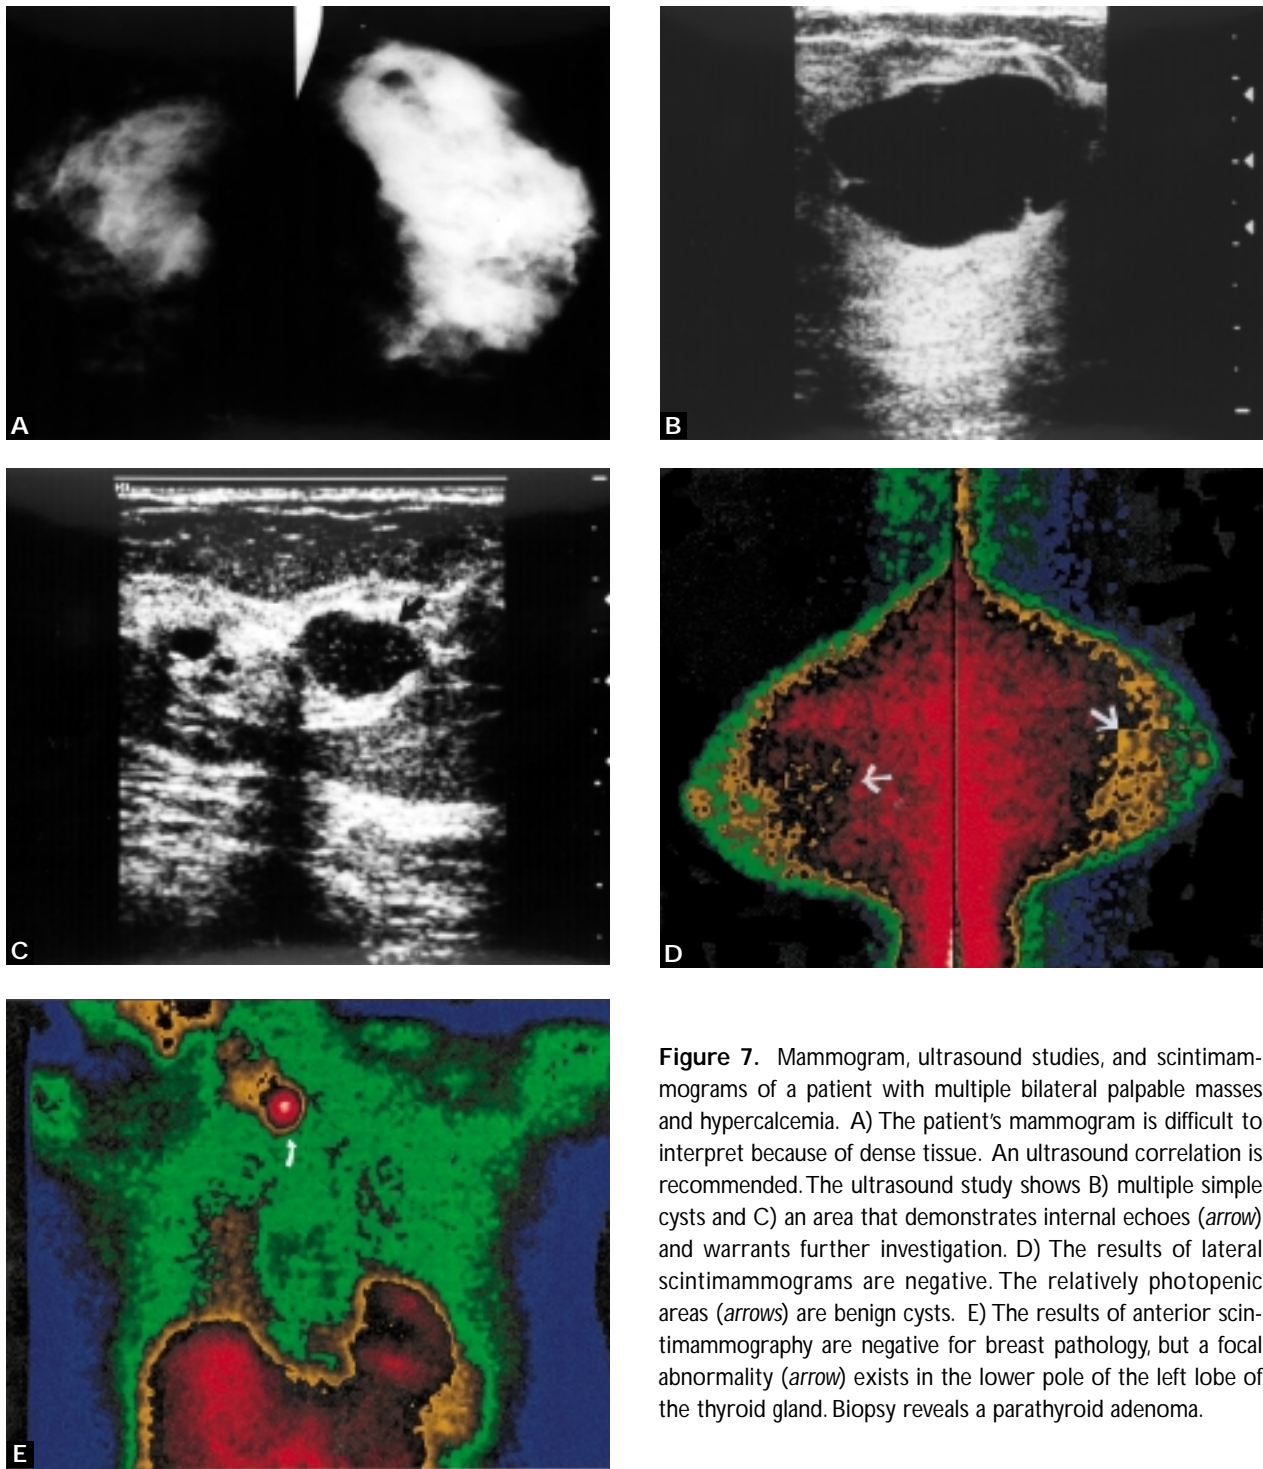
Mammogram, ultrasound studies, and scintimammograms of a patient with multiple bilateral palpable masses and hypercalcemia. A) The patient's mammogram is difficult to interpret because of dense tissue. An ultrasound correlation is recommended. The ultrasound study shows B) multiple simple cysts and C) an area that demonstrates internal echoes (*arrow*) and warrants further investigation. D) The results of lateral scintimammograms are negative. The relatively photopenic areas (*arrows*) are benign cysts. E) The results of anterior scintimammography are negative for breast pathology, but a focal abnormality (*arrow*) exists in the lower pole of the left lobe of the thyroid gland. Biopsy reveals a parathyroid adenoma.
